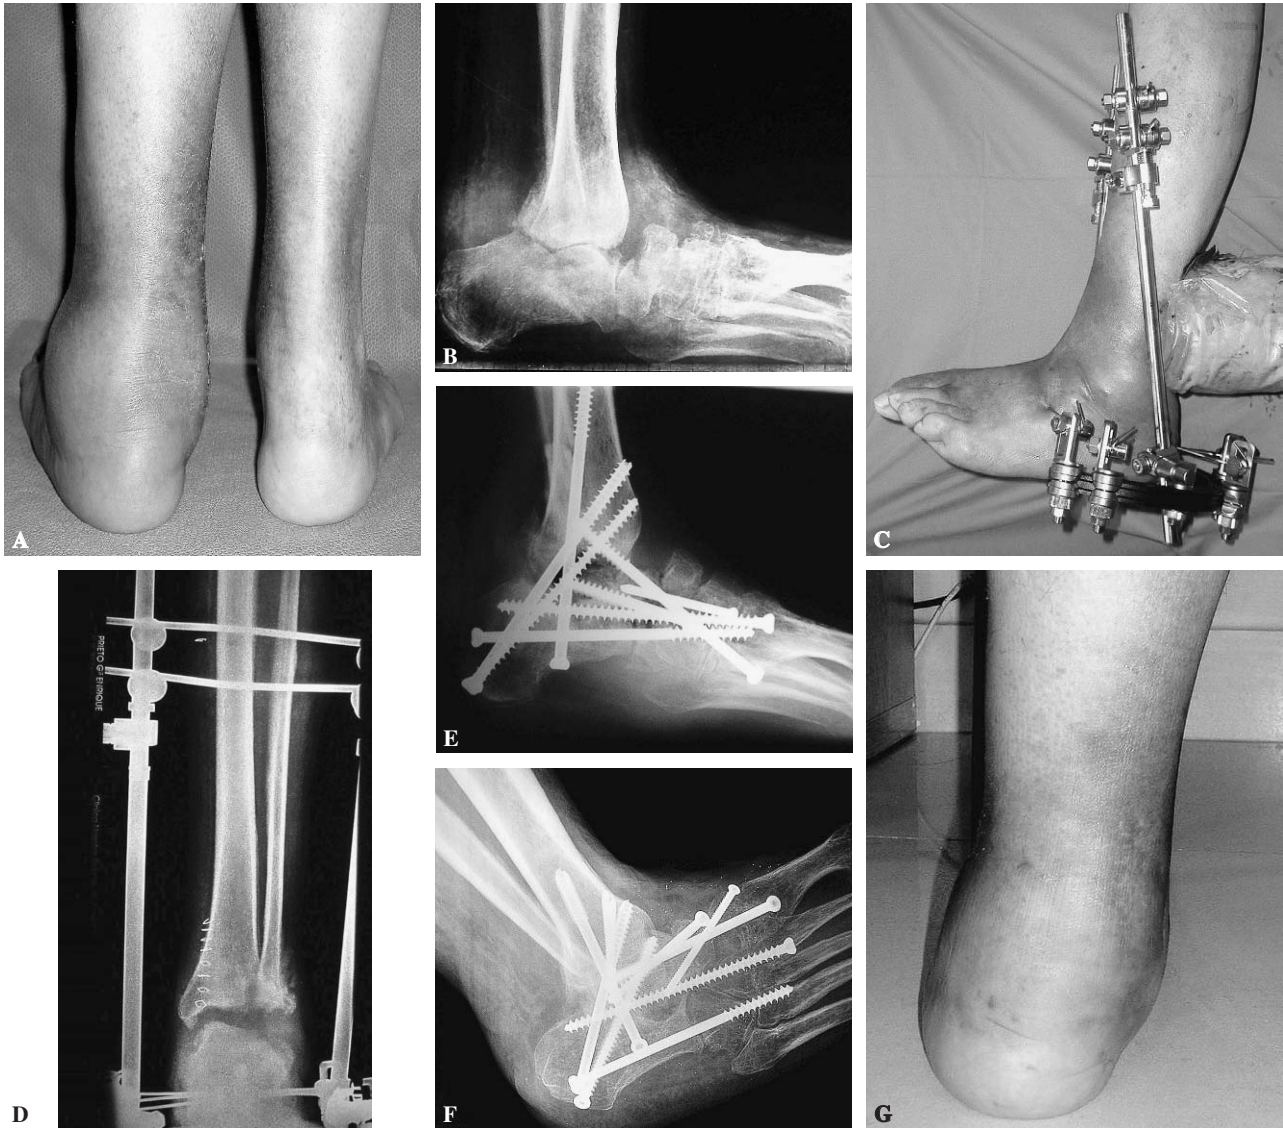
A: A posterior view of a 46-year-old patient with diabetes mellitus type II and Charcot foot. It is possible to see a significant deformity and swelling of the hindfoot. B: Lateral X-ray projection in which it is possible to see a lateral dislocation of the calcaneal beneath the fibula. The tibia articulates with the body and neck of the partially disintegrated talus and it is possible to see instability of the Chopart joint and collapse of the medial column. C: Lengthening of the Achilles tendon was performed and a hybrid external fixator was used to achieve distraction and reduction of the calcaneal beneath the talus. Pins were placed in the proximal tibia, the posterior tuberosity of the calcaneal and bones of the tarsus. D: An antero-posterior projection of the ankle confirms the reduction of the calcaneal beneath the talus and the disintegration of the fibular malleolus. E: Lateral projection in which it is possible to see a reduction of the unstable ankle and hindfoot, with a double fusion that extends to the Chopart joint, the medial column and the Lisfranc joint. Bank allograft was used to fill in the defects. F: In an oblique projection it is possible to see the extension of the ankle fusion before fibular osteotomy to access said joint. Alignment and stability improve. G: Posterior view of the foot and ankle after reconstruction with a slight residual valgus. The patient now walks without crutches using a double insert and footwear with a rocking chair sole. The patient has returned to his usual work as a bank employee.
